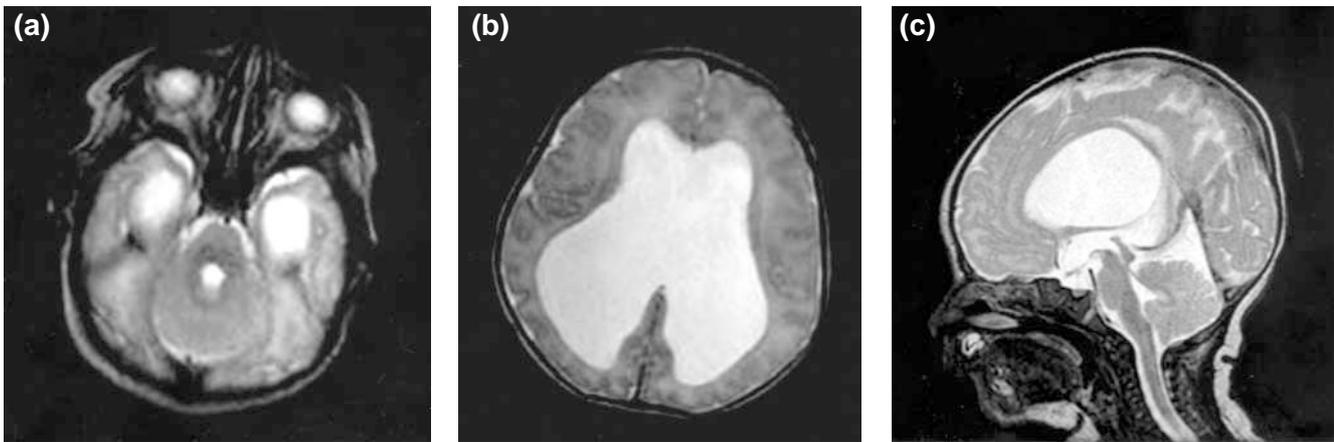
(a) Axial MRI T2 weighted images at 3-day-old, showing a diamond-shaped fourth ventricle. No intervening vermis was seen between the fused cerebellar hemispheres. The temporal horns were dilated; (b) There was hydrocephalus and the septum pellucidum was absent; (c) Sagittal MRI T2 weighted image revealed evidence of aqueductal stenosis and hypoplastic corpus callosum.
